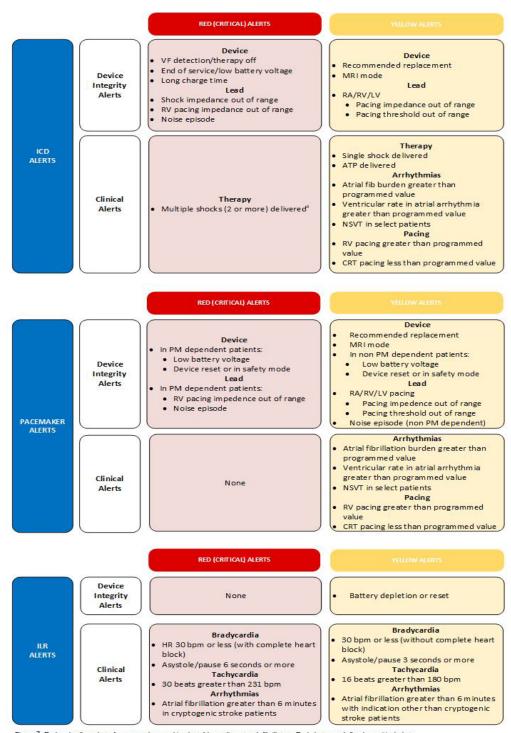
Red and yellow alerts for pacemakers and implantable cardioverter-defibrillators. Red alerts are defined as critical alerts requiring urgent review. Yellow alerts are those that, with early review, may lead to an action that impacts patient outcomes. «Multiple shocks could demonstrate clinical deterioration or be ineffective. ATP 5 anti-tach yeardia pacing; bpm 5 beats per minute; CRT 5 cardiac resynchronization therapy, LV 5 left ventricular; ICD 5 implantable cardioverter-defibrillator; ILR 5 implantable loop recorder; MRI 5 magnetic resonance imaging; NSVT 5 nonsustained ventricular tach yeardia; PM5 pace-maker; RA 5 right atrial; RV 5 right ventricular; VF 5 ventricular fibrillation.
